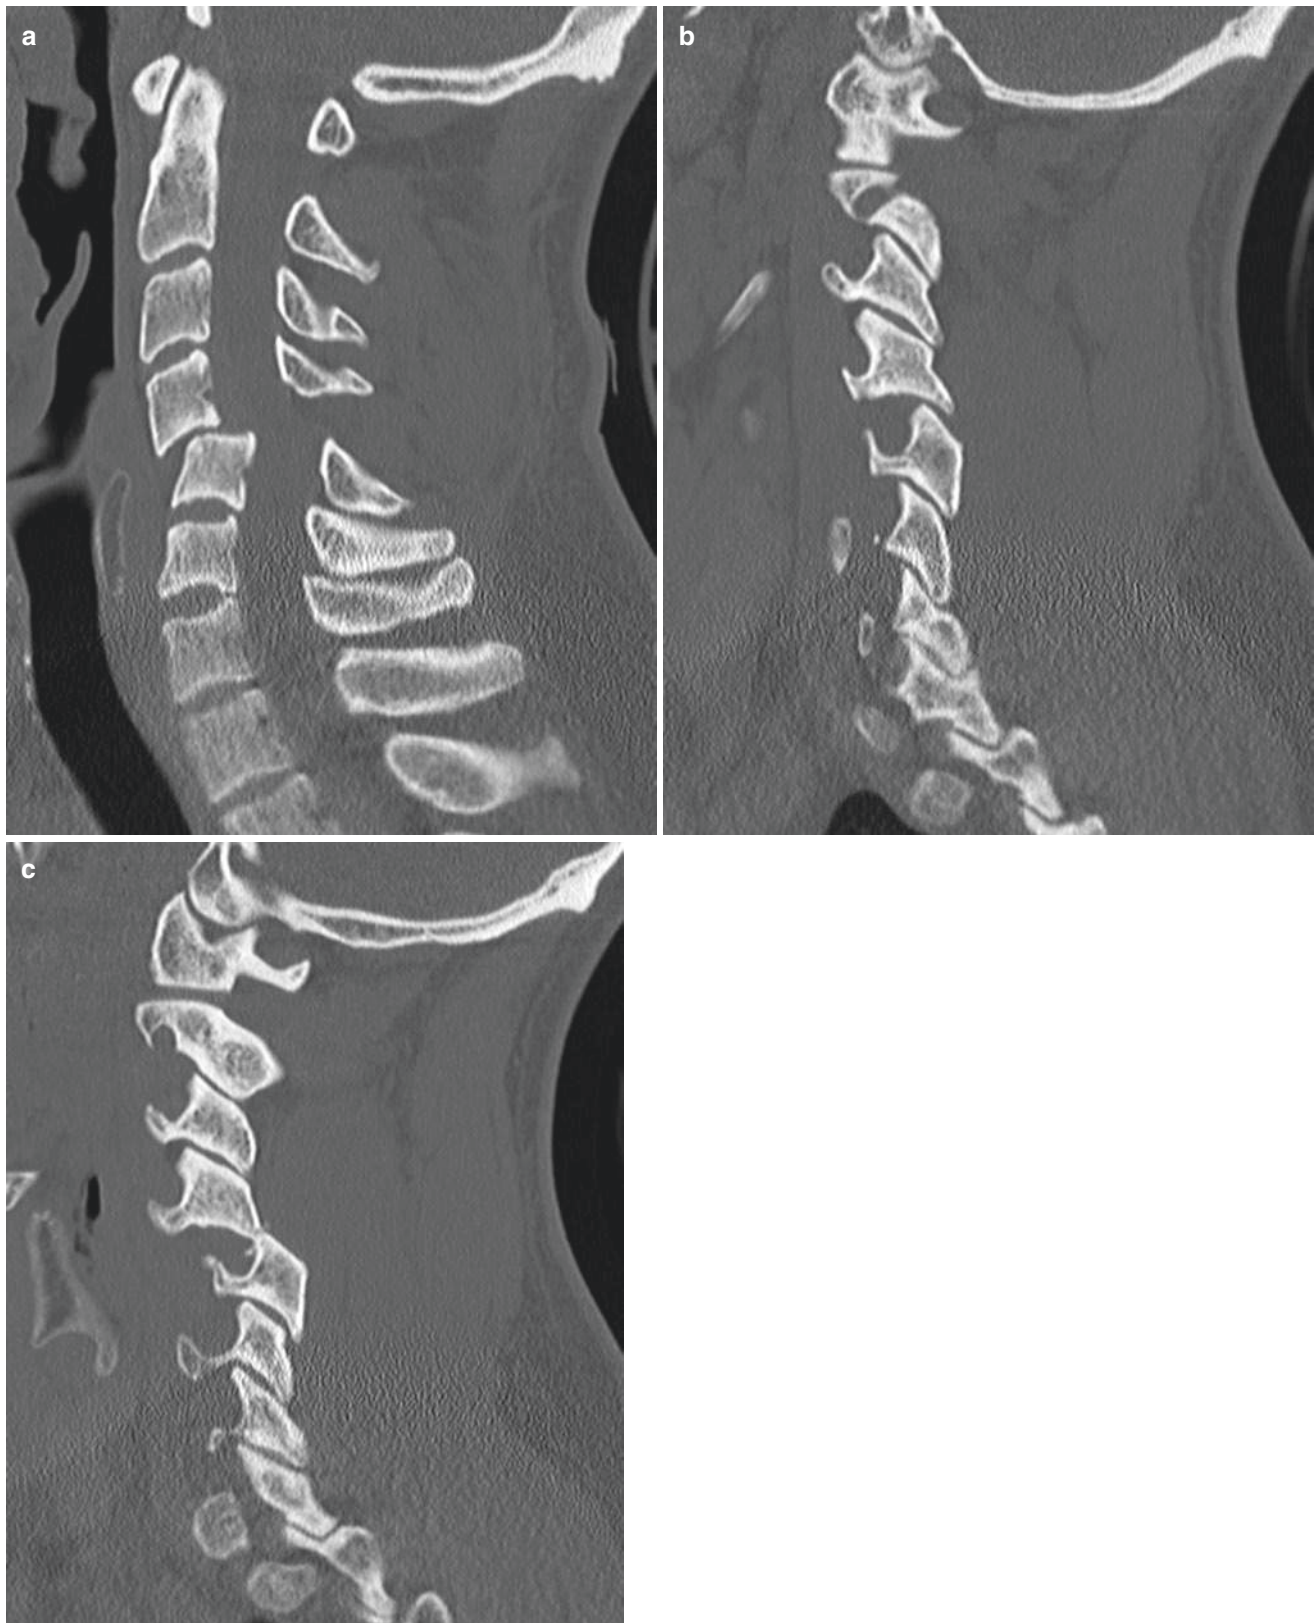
30 year old male footballer sustained an acute injury during a tackle. CT bone reconstructed sagittal plane images shows (a) C4-5 fracture dislocation with (b) facet fracture dislocation on one side and (c) subluxated facet on the other side
